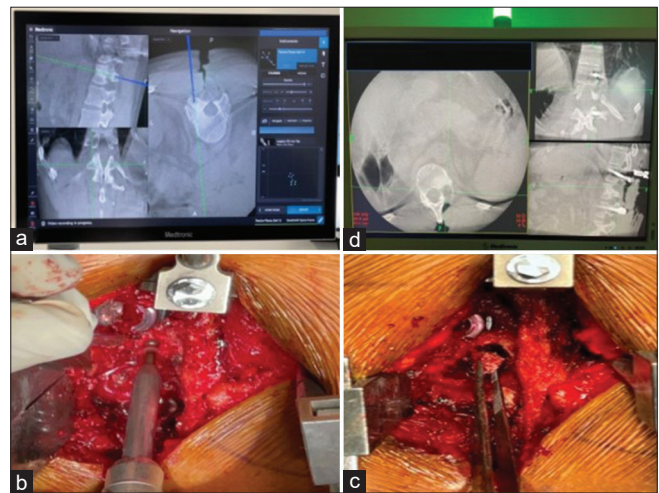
Intraoperative navigation and clinical images; (a) navigation-guided exact location of nidus, (b) burring superior articular process of D12, (c) excised nidus, and (d) postoperative O-arm 3D CT confirming complete excision of tumor.
